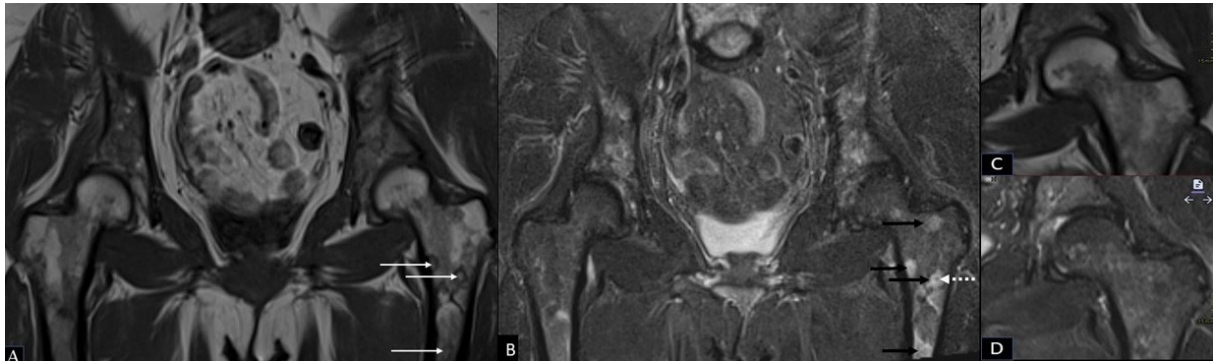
Coronal T1-weighted (A) and STIR images of the pelvis (B) show extensive multifocal intramedullary lesions in the proximal femurs that demonstrate T2 hypertense signal (black arrows) with intrinsic T1 hyperintense signal (white arrows) and corresponding low signal on STIR (broken white arrow): These findings are in keeping with large bone sarcoidosis in a patient with known history of sarcoidosis. Follow-up coronal T1-weighted (C) and STIR (D) MRI images of the left hip performed 4 years later demonstrates complete resolution of the lesions.
